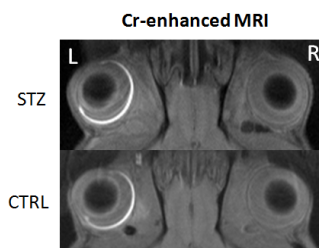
Cr-enhanced MRI of the retina at 1 day after Cr injection into left eye and 1 month after STZ or citric acid (CTRL) injection.
